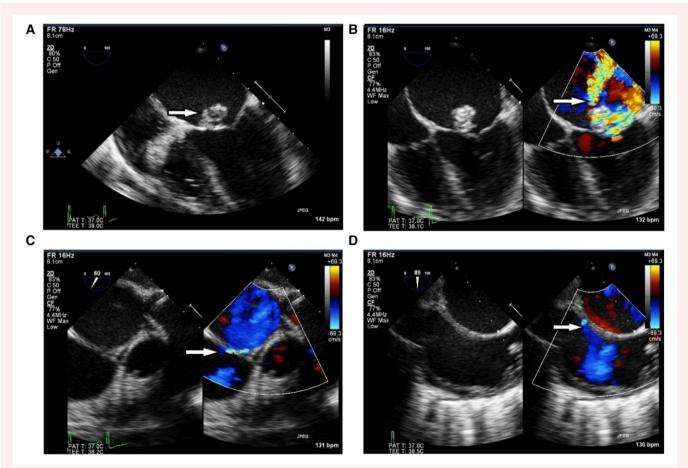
Intraoperative transoesophageal echocardiogram. (A, B) Large and very mobile vegetation on the anterior leaflet of the mitral valve with severe mitral regurgitation. (C) Short-axis view demonstrating left-to-right flow across the patent foramen ovale [left atrium (LA) end 1.6 mm, right atrium (RA) end 2.6 mm, and tunnel length 1.6 mm]. (D) Bicaval view demonstrating the PFO demonstrating left-to-right flow across the patent foramen ovale.
